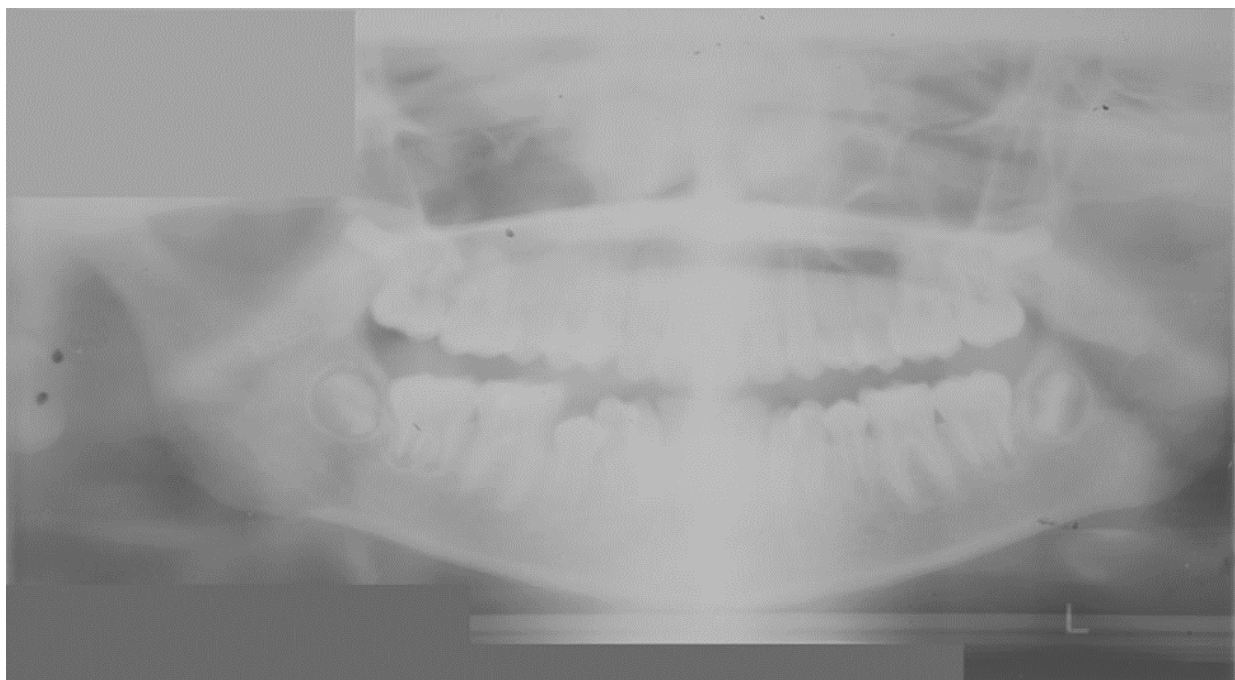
Blurred radiograph from the Economides collection
